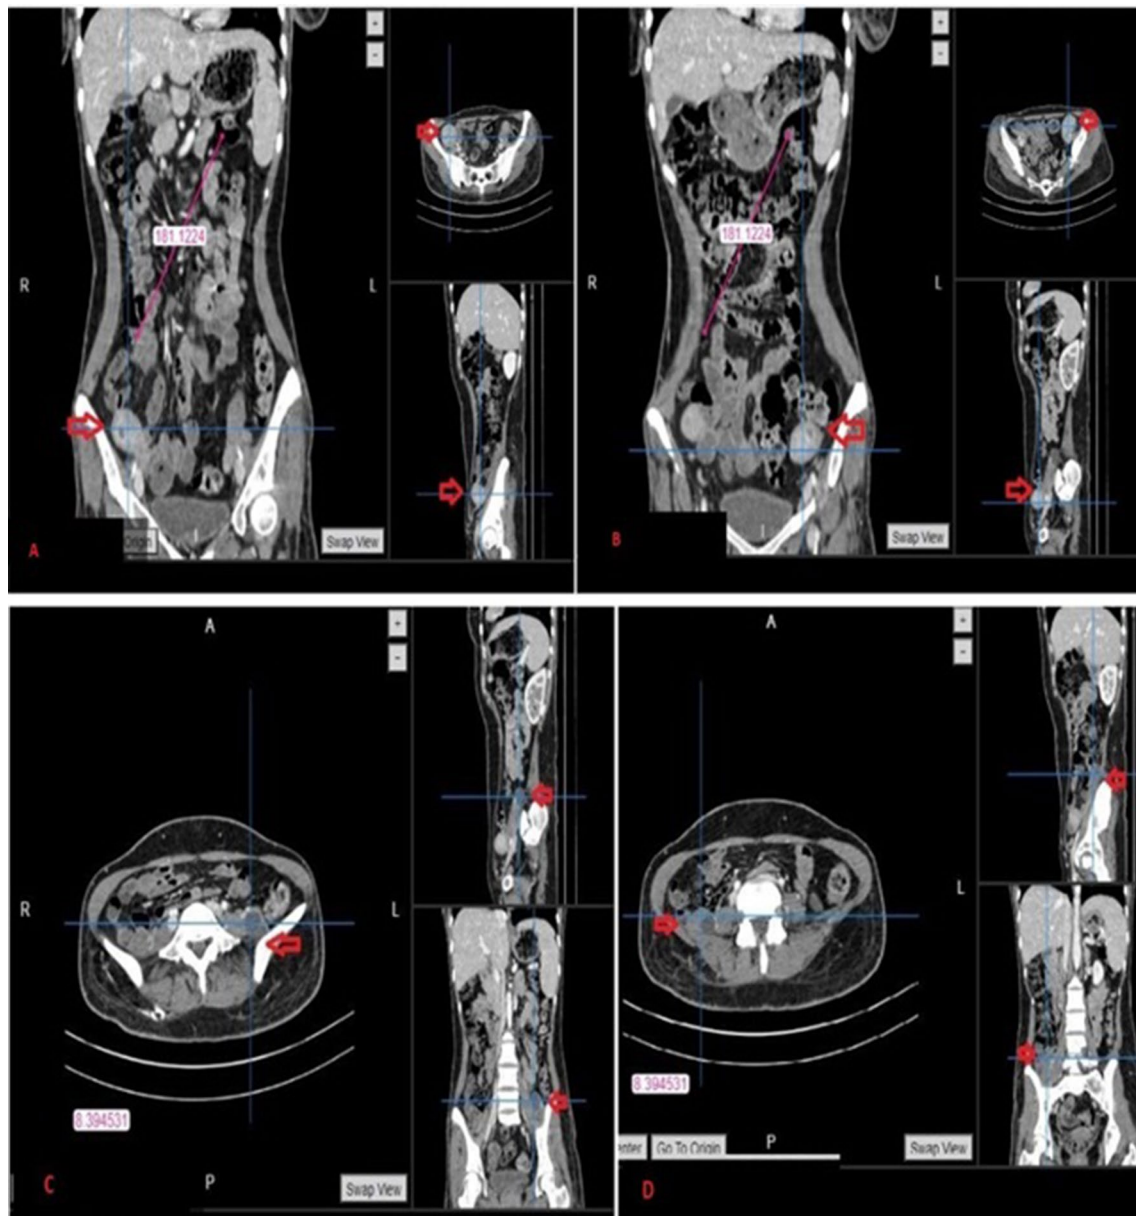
CT scan with multi-planar reconstruction a indicating the right corn of didelphis uterus. CT scan with multi-planar reconstruction b indicating the left corn of didelphis uterus (all intended structures are indicated by arrow). CT scan with multi-planar reconstruction c indicating the left ovary in abnormal position, also CT scan with multi-planar reconstruction d indicating the right ovary in abnormal position (all intended structures is indicated by arrow)
